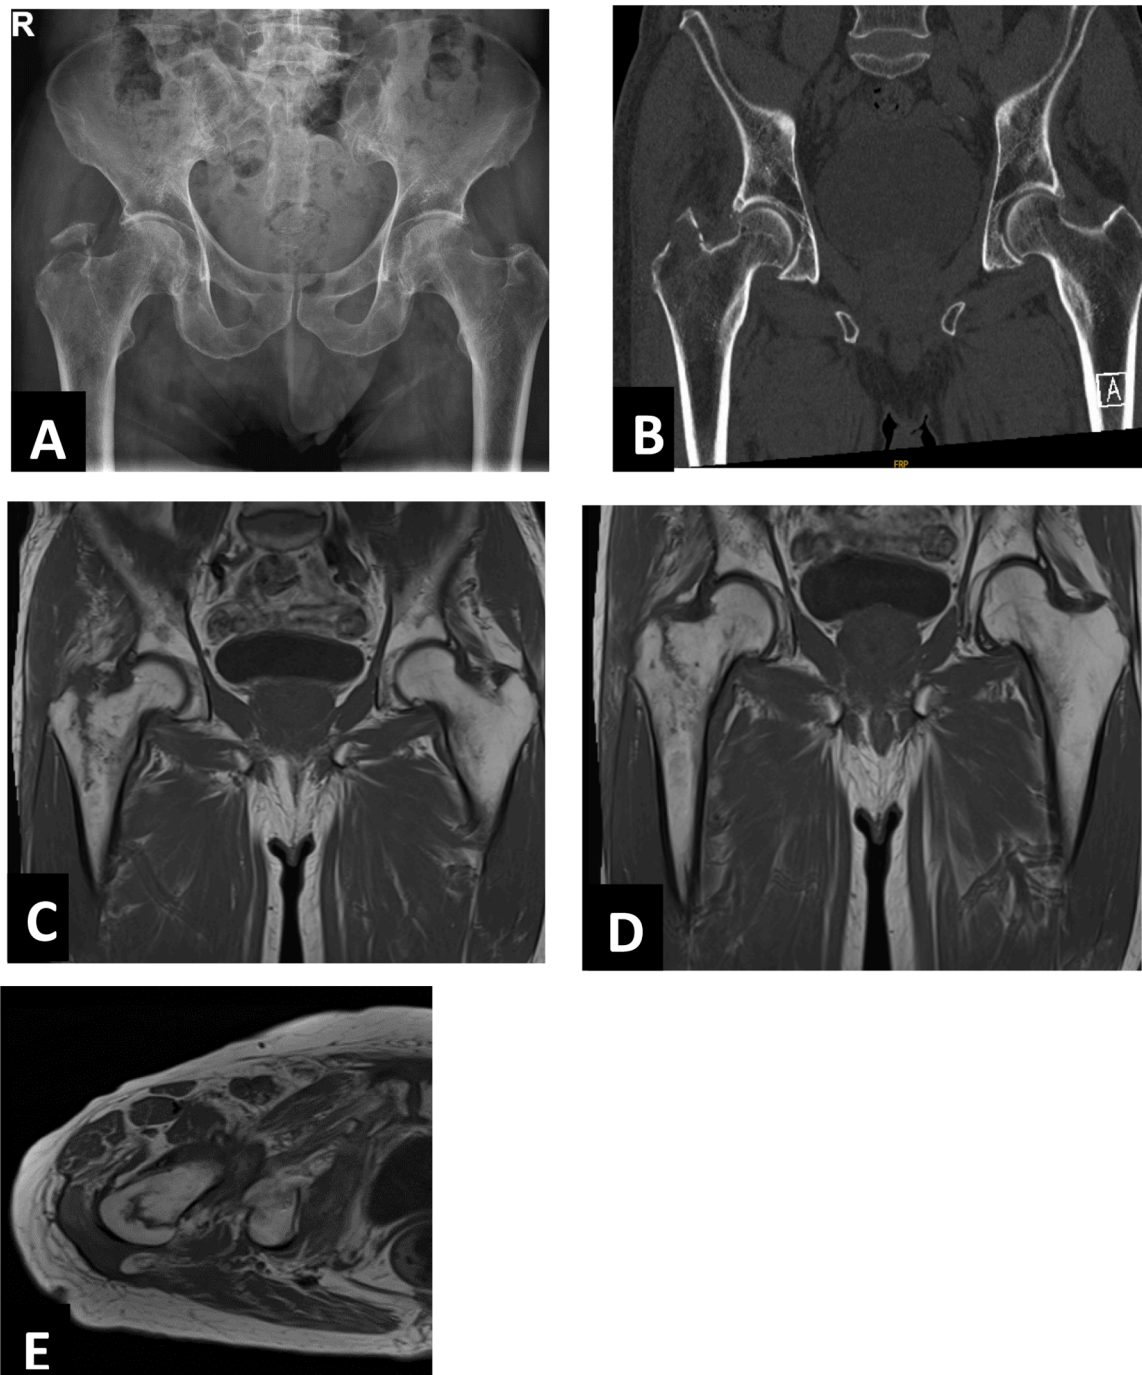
(A–E) Images of 77 years male sustaining a fall on his right side. This patient was diagnosed with a right GT fracture on plain radiograph, CT and MRI were conducted as part of our diagnostic protocol. Fig. A- Plain radiograph showing GT fracture with no extension to the Intertrochanteric region. Fig. B- CT coronal cut showing the GT fracture with no visible extension to the intertrochanteric region. Fig. C- Coronal T1 sequences MRI image, showing a line with low signal extending from the fracture to the in the intertrochanteric region. Fig. D- Mid Coronal T1 sequences MRI image, showing a line with low signal extending from the fracture to the intertrochanteric region. Fig. E- Axial plane T1 sequences MRI image, showing a line with low signal extending to the anterior cortex.
